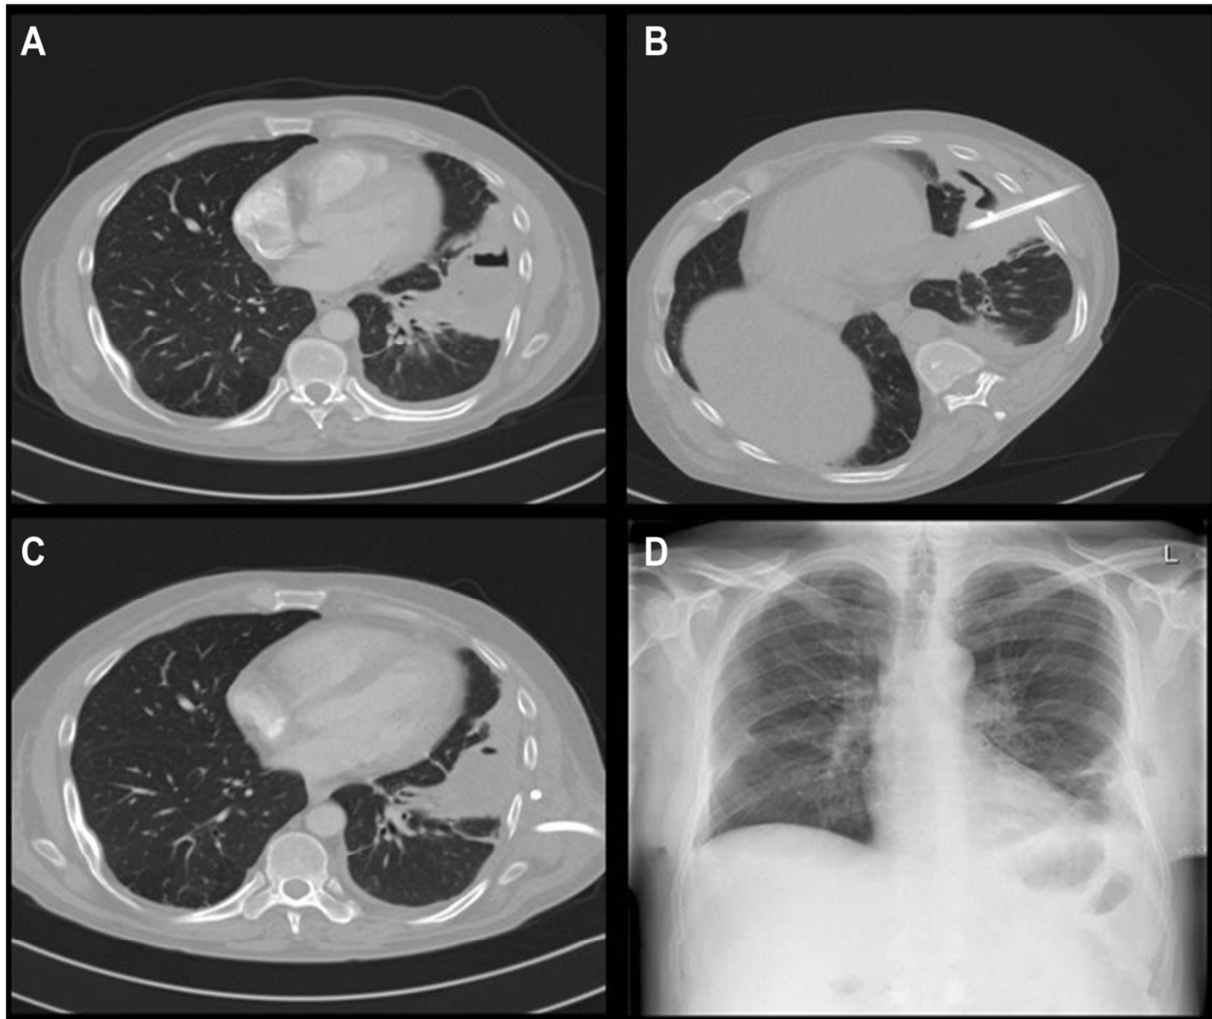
Morphological features of the course of conservative therapy and follow-up. (A) CT scan revealed a disintegrated mass of the left lower lobe. (B) Insertion of percutaneous catheter drainage. (C) Catheter dislocation. (D) Chest X-ray after VAC Therapy and before discharge.
